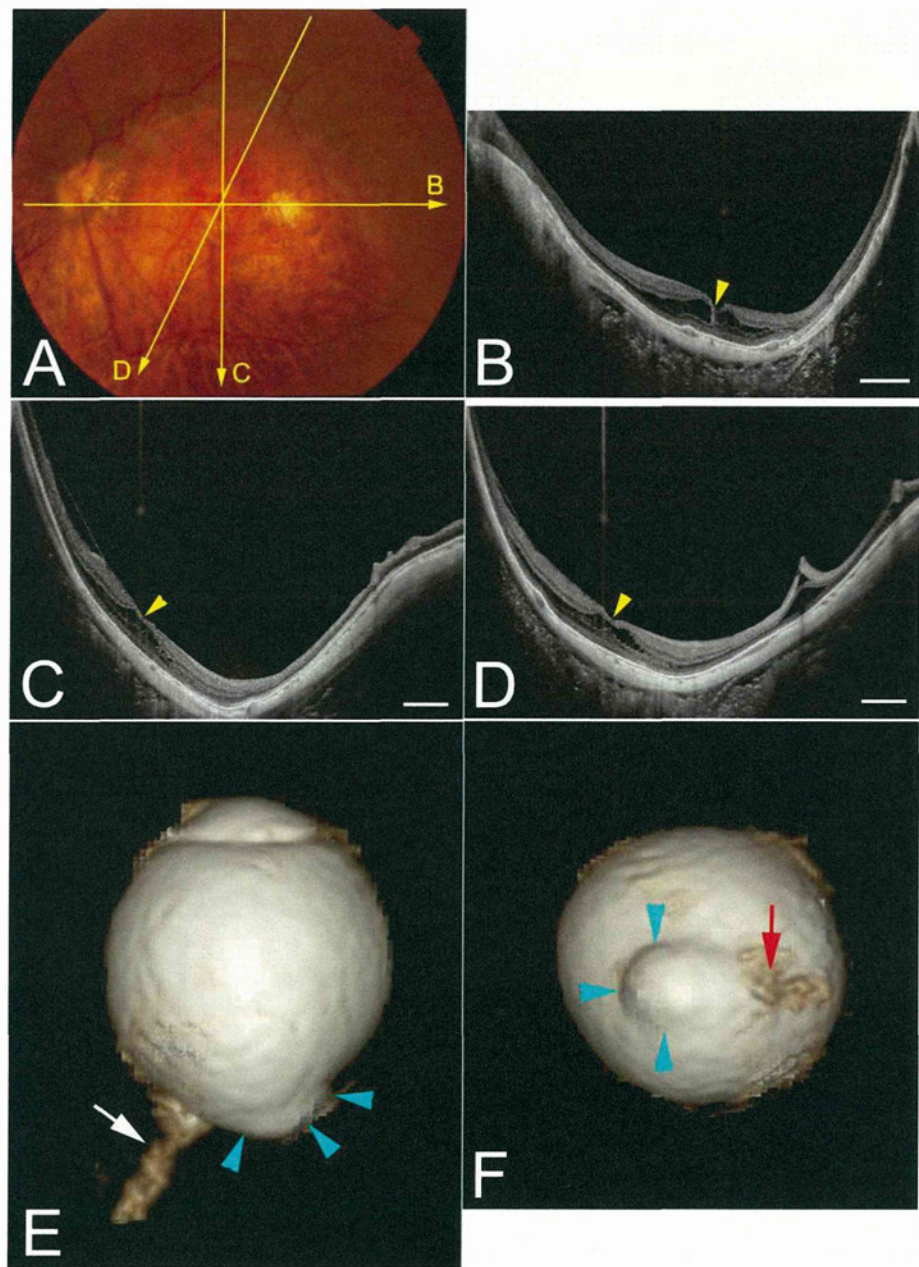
OCT image of a highly myopic eye with asymmetrical curvature of the sclera and 3D MRI image of the same eye showing an inferiorly distorted eye. (A) Photograph of the left fundus of a 68-year-old woman with an axial length of 28.2 mm (intraocular lens-implanted eye) showing a temporal conus around the optic disc. Yellow lines show scanned lines by OCT in (B) and (C). (B) Horizontal OCT scan showing that the most protruded point is slightly nasal to the central fovea (arrowhead). ON, optic nerve. Scale bar = 1 mm. (C) Vertical OCT scan showing that the most protruded point is inferior to the central fovea. The fovea (arrowhead) is on the slope. Scale bar = 1 mm. (D) Inferior view of 3D MRI image of the eye shows that the globe is elongated symmetrically in the horizontal plane. The optic nerve (arrow) is situated within the protrusion shown by the arrowheads. (E) Posterior view of 3D MRI image of the eye shows that the protrusion (arrowheads) is located inferiorly. The optic nerve (arrow) is located within the nasal margin of the protrusion.
